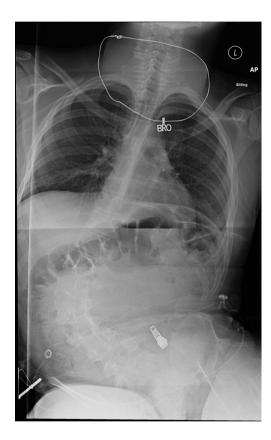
Preoperative radiograph of a child with cerebral palsy and scoliosis.
